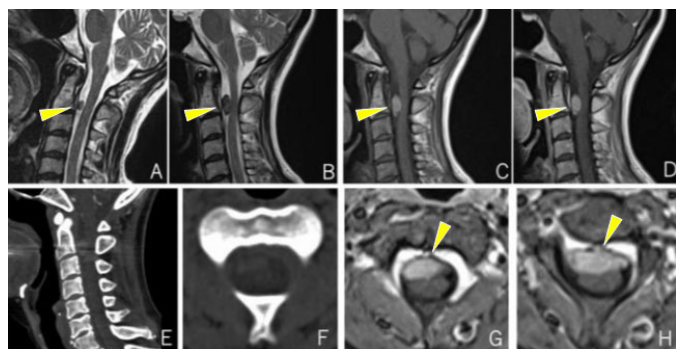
Preoperative cervical MRI and CT. (A) Sagittal T2-weighted image showing an extradural mass at C2 level at first diagnosis (yellow arrow head). (B) Sagittal T2-weighted image after 6 years of follow-up. Tumor gradually growing and compressing the spinal cord (yellow arrow head). (C) Sagittal T1-weighted image (yellow arrow head). (D) Sagittal T1-contrast-enhanced image (yellow arrow head). (E) Sagittal contrast-enhanced CT. (F) Axial contrast-enhanced CT. (G, H) Axial T1-weighted contrast-enhanced image (yellow arrow head).
